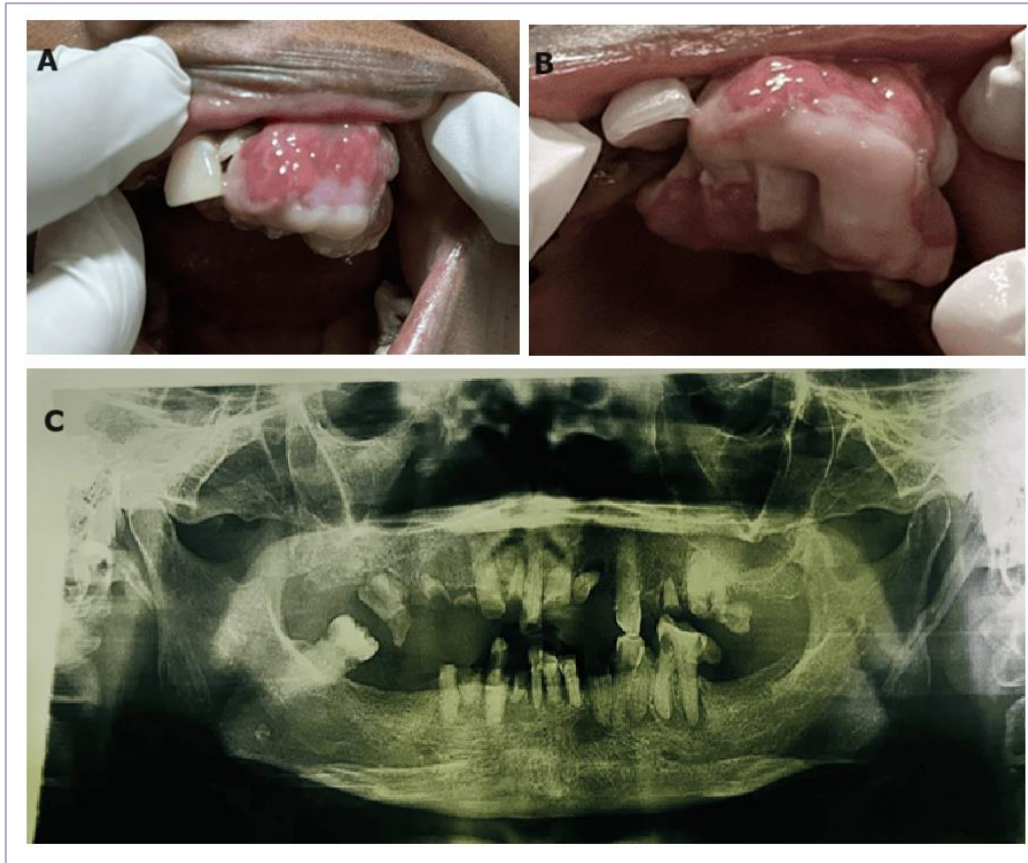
Case report Photo. (A, B) Clinical examination photo, (C) Radiographic Image.
